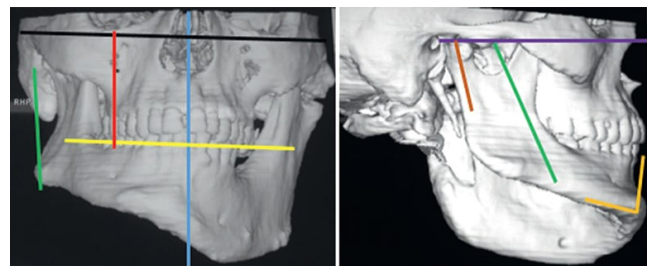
a, b. 3D-CT face analysis for assessing the facial asymmetry
